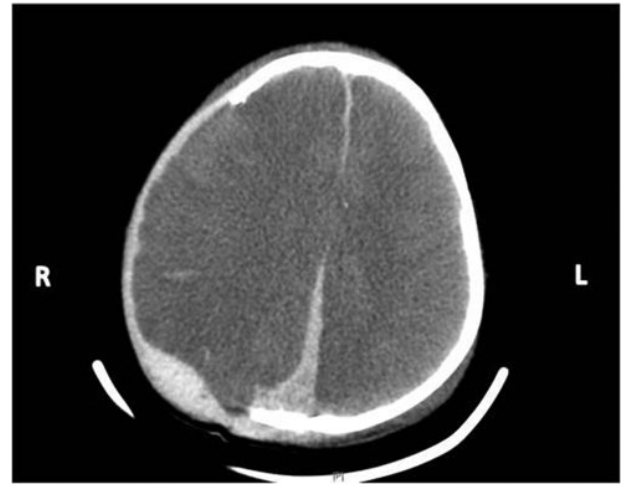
CT head without contrast in an 18-month-old victim of a motor vehicle crash showing a right extra-axial hematoma measuring up to 17 mm with subarachnoid and intraparenchymal hemorrhage in the right temporoparietal lobes.
